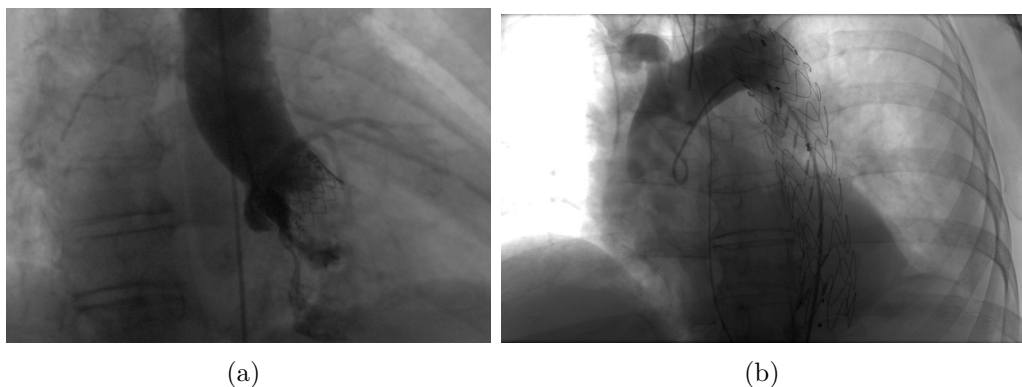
Examples of 2D X-ray images used for guiding minimally invasive cardiac procedures. (a) X-ray image depicting aortic valve implant in aortic root. (b) X-ray image for catheter guidance during endovascular thoracic aortic stenting procedure.
